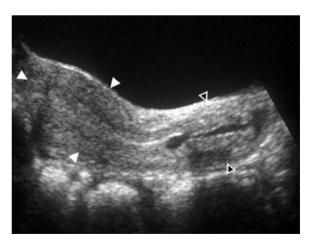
Normal postmenarchal uterus of a 12-year-old girl. Longitudinal sonogram: pear-shaped uterus. Diameter and length of the fundus (*closed arrowheads*) are greater than those of the cervix (*open arrowheads*)
